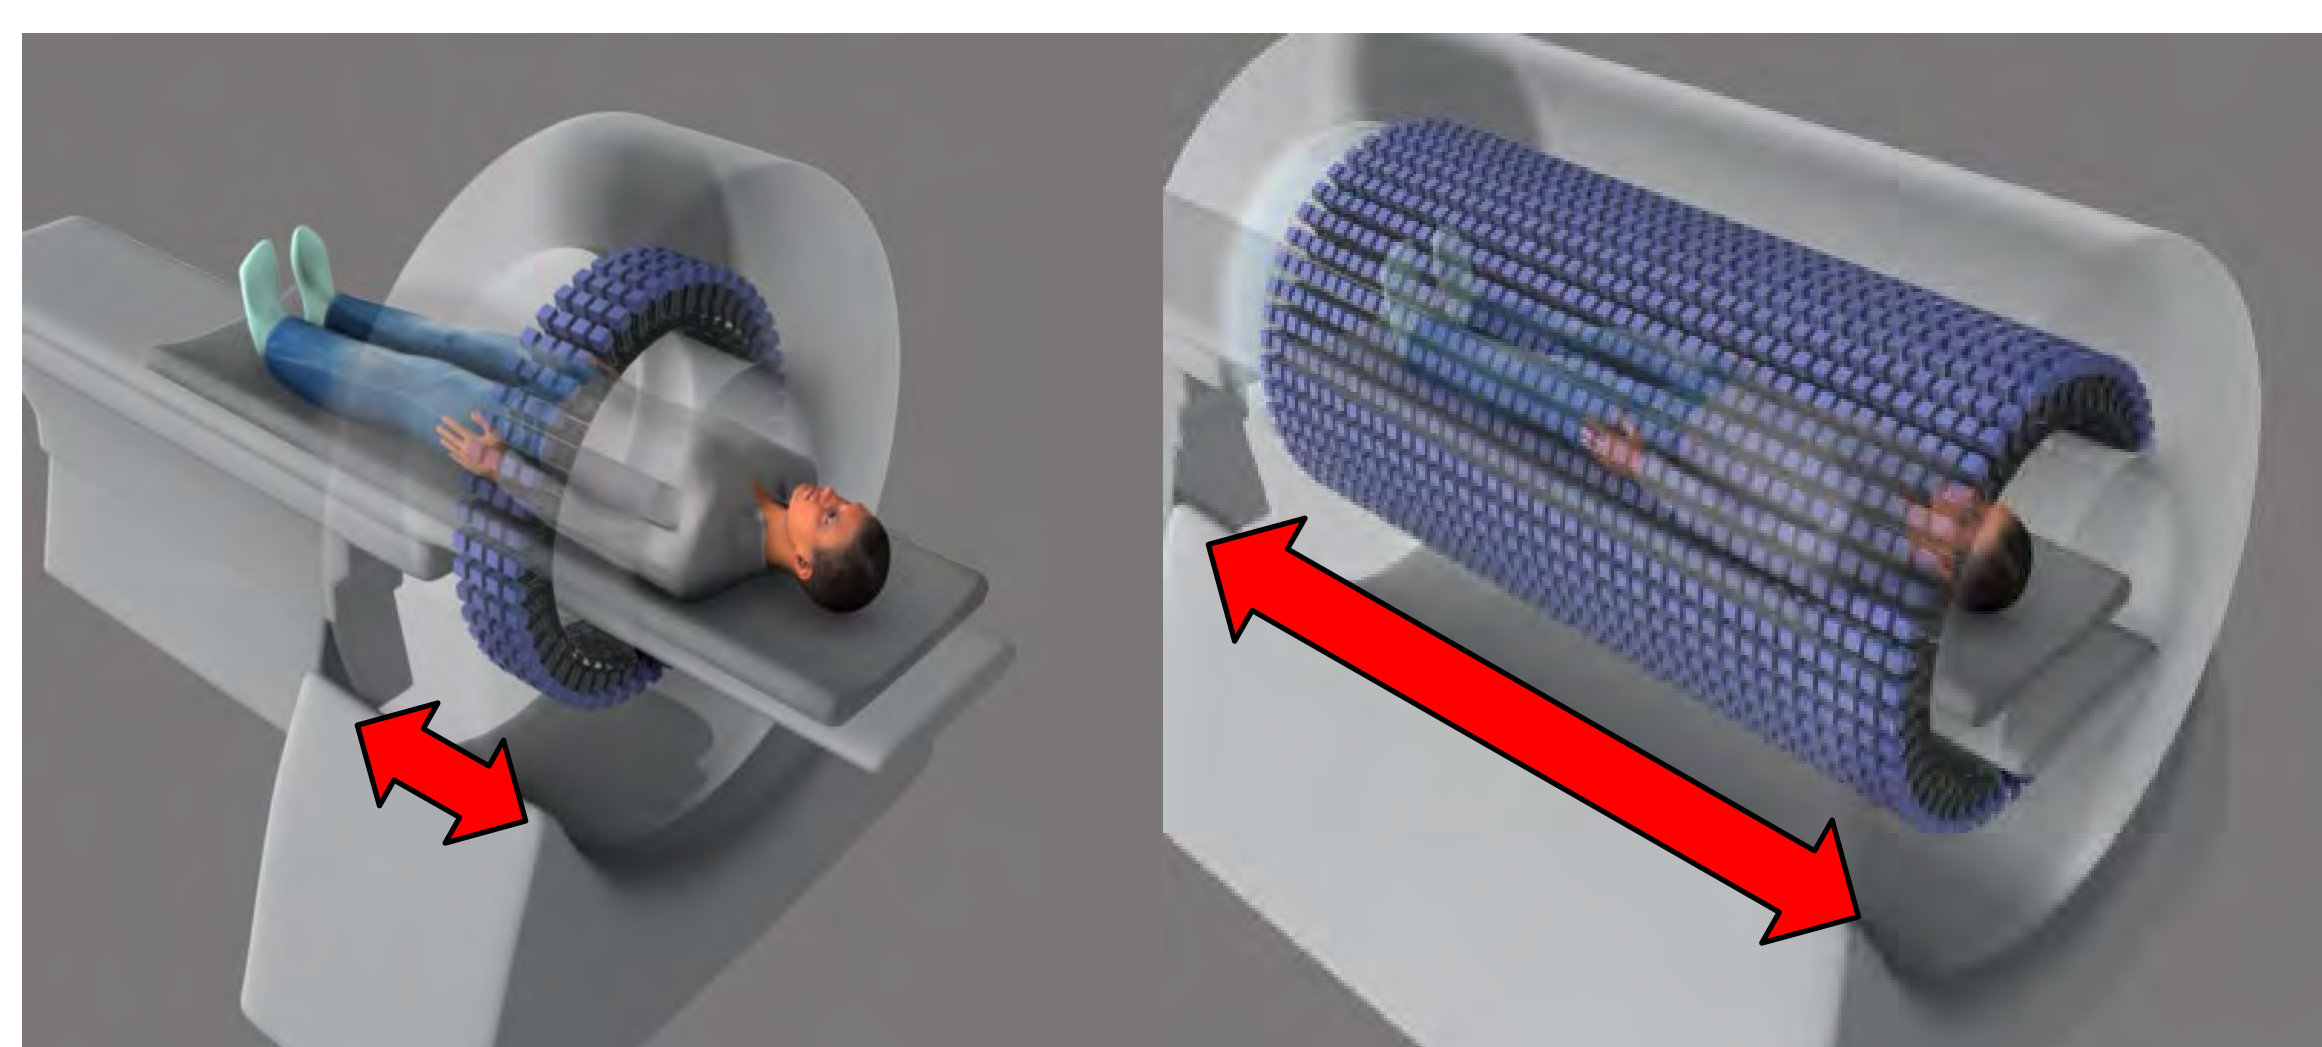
Comparison of conventional vs total body PET/CT
